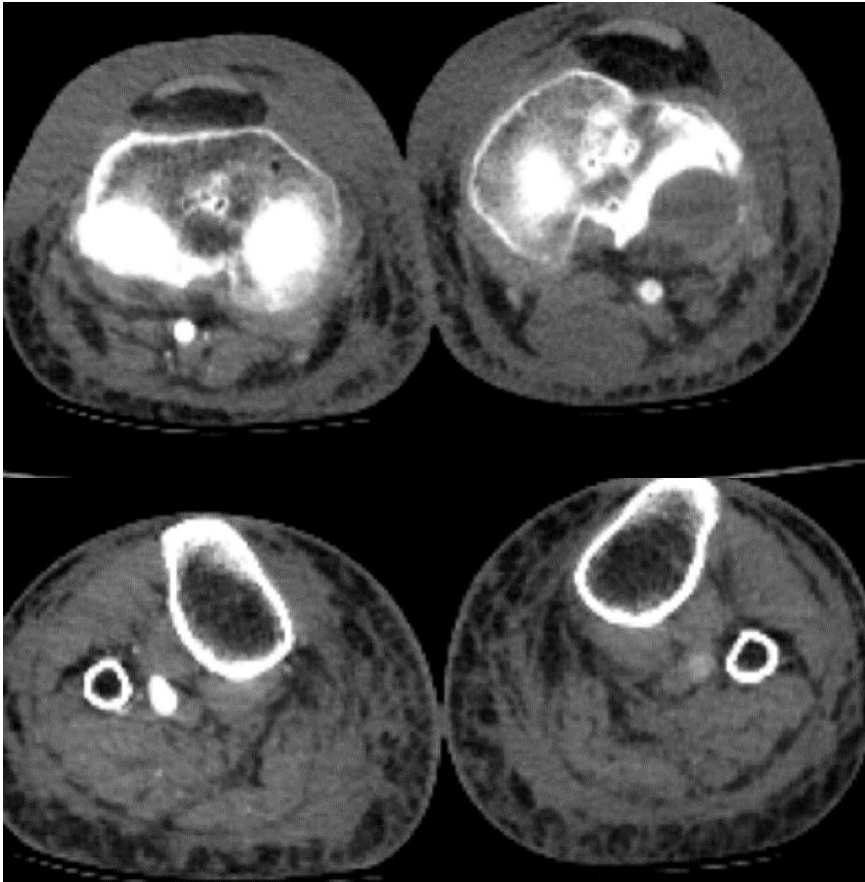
5: Selected participant's CTA images showing features of left lower limb PAD in a 79-year-old female patient with Diabetes Mellitus and hypertension.
